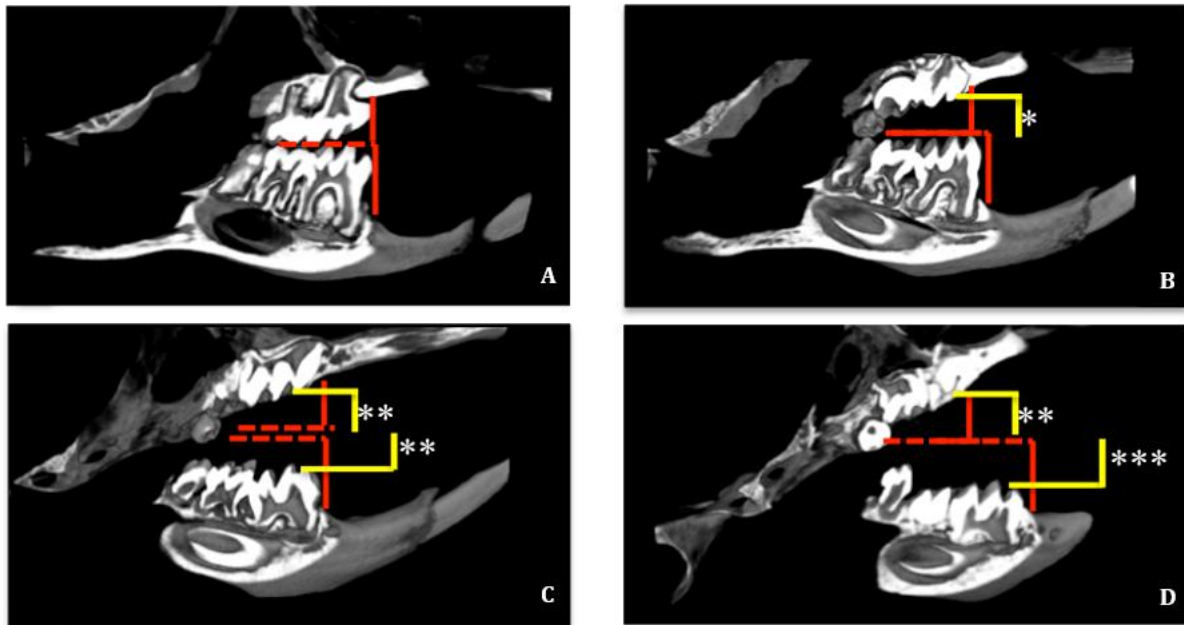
Micro CT parameters used to evaluate tooth eruption defects subsequent to the anti-RANKL antibody treatments.
